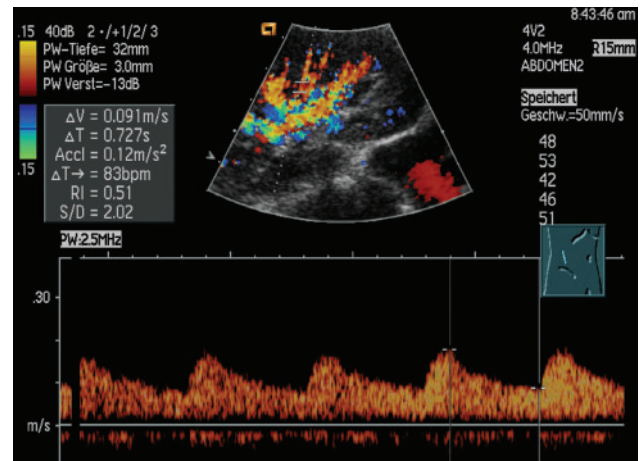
Intrarenal RI is derived from the formula of Pourcelot [16]. RI of 51 is determined in the Doppler flow pattern of a kidney with proximal RAS. The ‘tardus-parvus’-flow pattern reveals low peak systolic and high end diastolic velocity resulting in low RI-values from 42 to 53.
